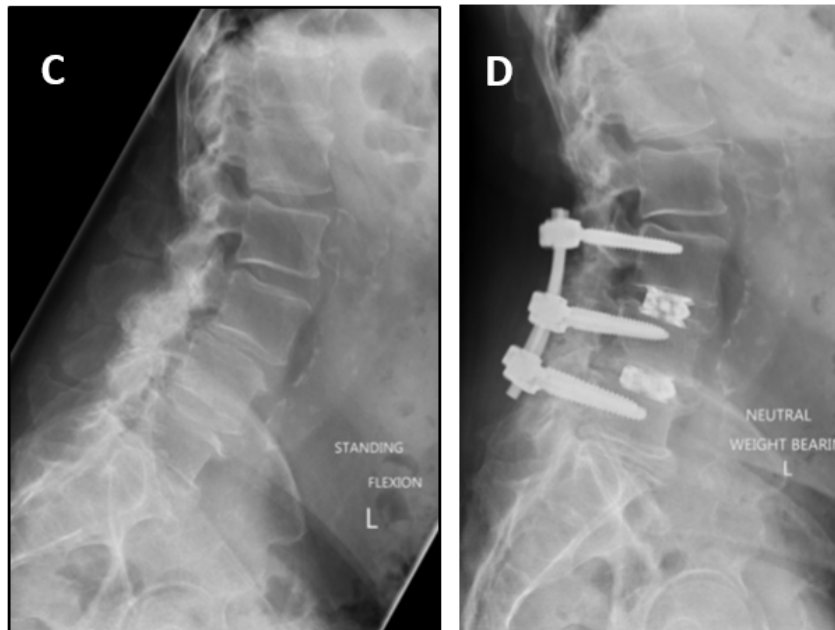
Preoperative lateral (C) and postoperative lateral (D) plain radiographic images of the lumbar spine. Disc height restored and spondylolisthesis reduced.
